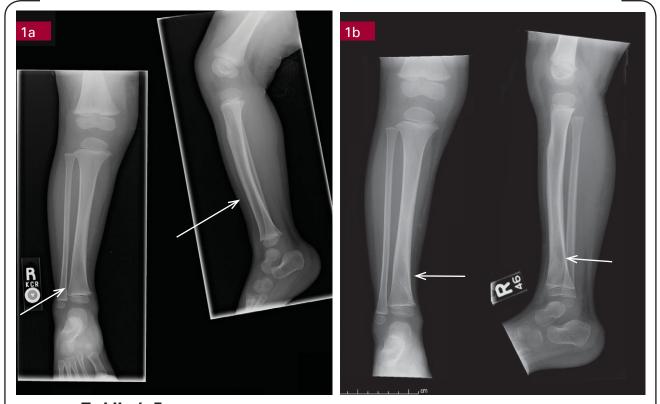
Toddler's Fracture. 1a. AP radiograph of the tibia revealing a toddler's fracture. 1b. Lateral radiograph of the tibia revealing a toddler's fracture.
